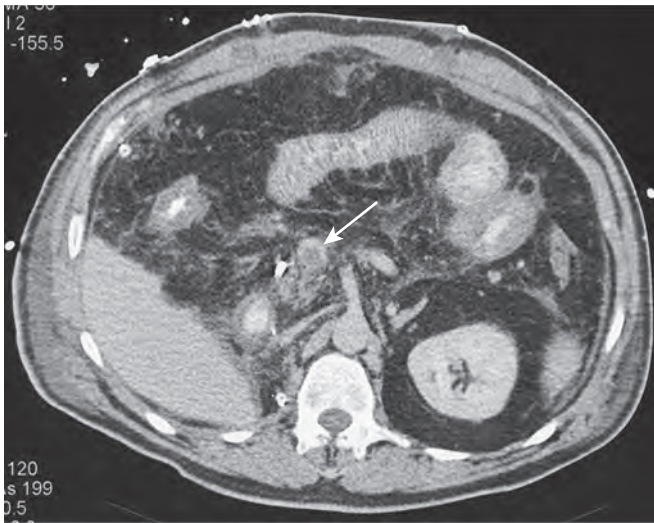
SMV thrombosis. Contrast-enhanced CT image in a patient with acute abdominal pain demonstrates thrombus in the SMV (arrow), with moderate thickening of the small bowel and right colon, which is concerning for bowel ischemia.
